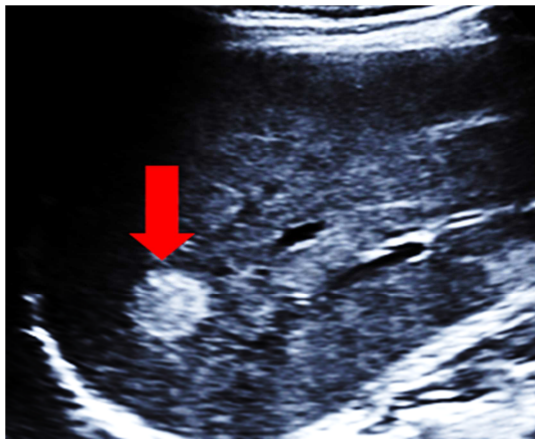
Ultrasonography shows the hemangioma as a hyperechoic mass with sharp margins.
